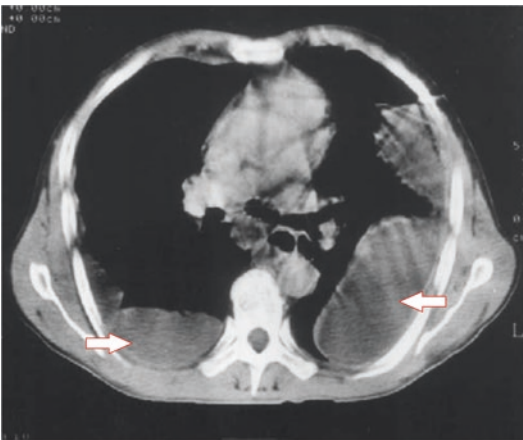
Contrast-enhanced computed tomography scan of the chest. Bilateral empyemas are evident (arrows), and there is also gas in the mediastinum. (From Karkos PD, Karkanevatos A, Panagea S, Dingle A, Davies JE. Lemierre's syndrome: how a sore throat can end in disaster. *Eur J Emerg Med* 2004;11:228–30 [39], with permission from Wolters Kluwer Health)
